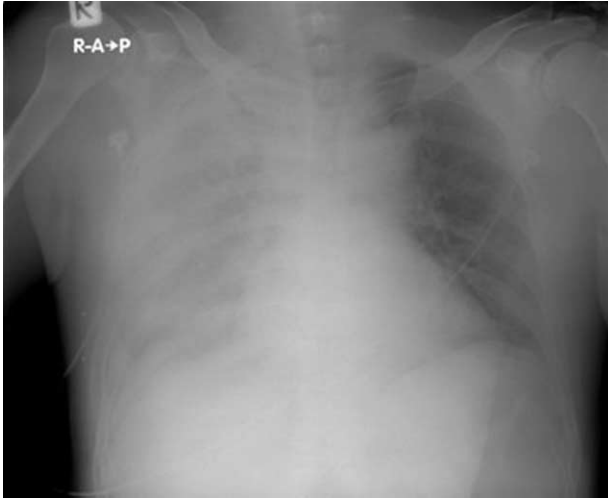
Chest radiograph showed widened mediastinum and large right pleural effusion.
